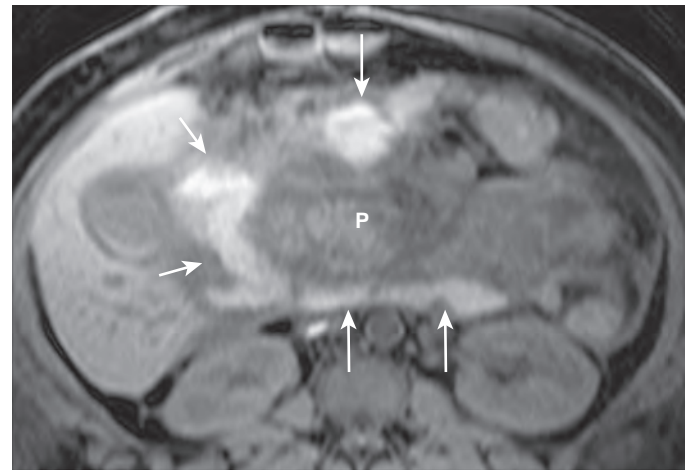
Pancreatitis with the development of high signal intensity fluid collections. Axial T1-weighted fat-suppressed spoiled gradient-echo MR image shows complex peripancreatic fluid collection (arrows) with predominantly high signal intensity, which extended inferiorly from the level of the pancreatic head (P). Aspiration biopsy revealed a necrotizing inflammatory process.
